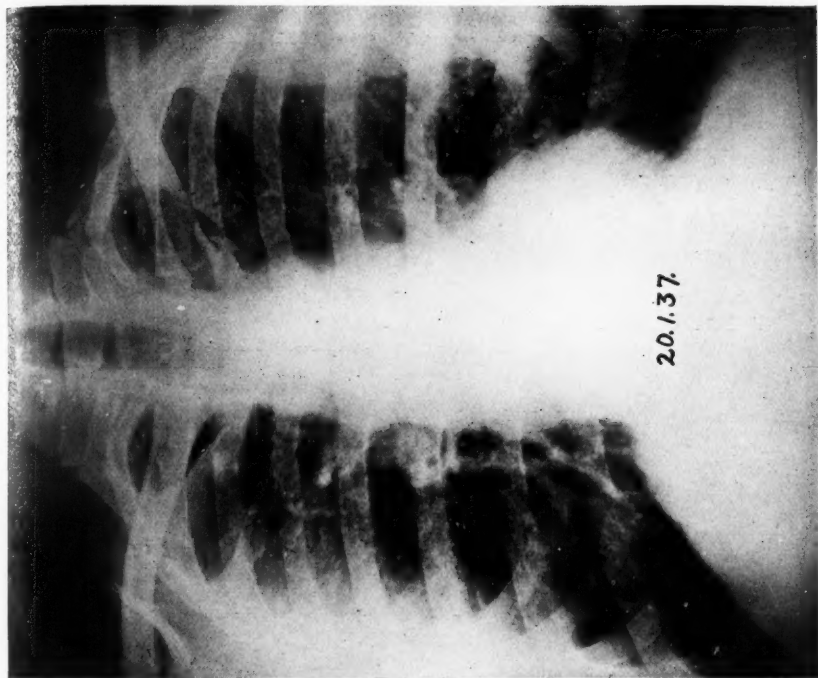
Case 1. X-ray of chest two years after operation
